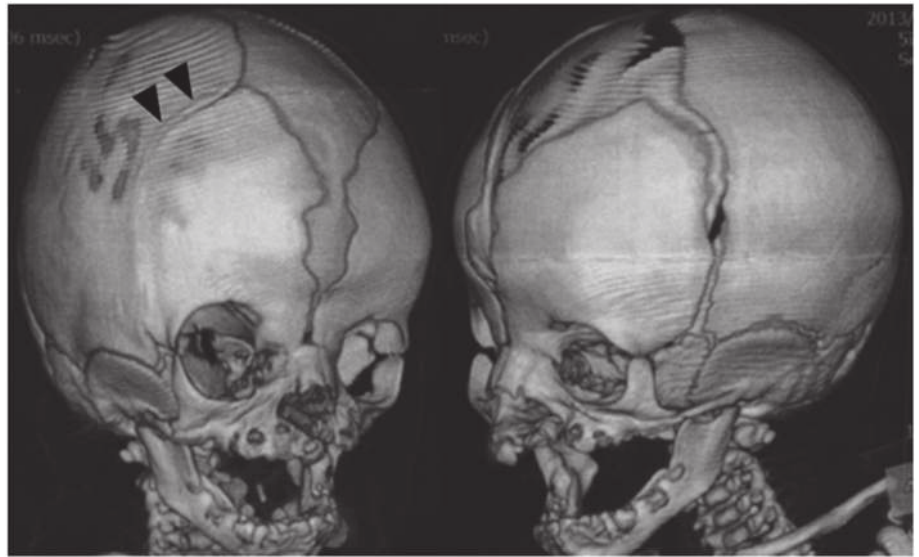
Three dimensional computed tomography (CT) image of patient at one month of age. Craniosynostosis of the right coronal suture is shown (arrowheads).
